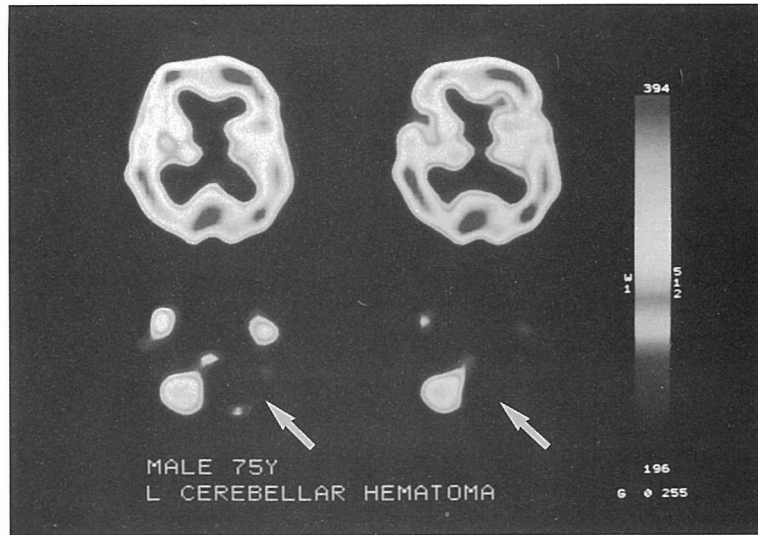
IMP-SPECT image of left cerebellar hemorrhage in case 1 shows no uptake in left cerebellum (arrows) and a slightly reduced uptake in right cerebrum compared to left side.
